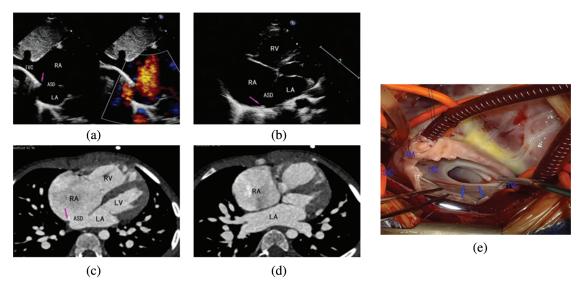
Images of "secundum ASD" adjacent to inferior vena cava. (a) Echocardiographic subcostal sagittal view demonstrated that secundum ASD was adjacent to inferior vena cava, but a posterior and inferior atrial septal rim (arrow) was present. (b) Apical four-chamber echocardiographic view. ASD and posterior atrial septal rim (arrow) were shown. (c) Posterior atrial septal rim was also detected by CT. (d) Right and left pulmonary veins returned normally. (e) ASD and posterior atrial septal rim (arrow) (ASD, atrial septal defect)
